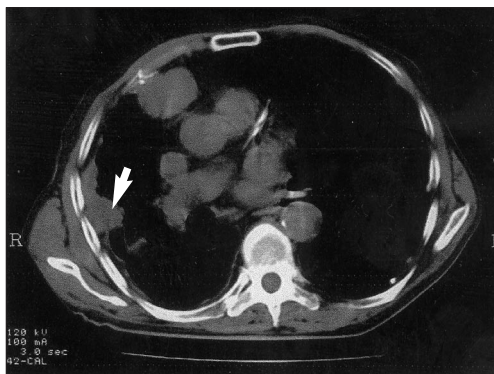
Computed tomography scan appearance of malignant mesothelioma (arrowhead).
